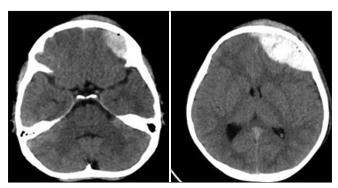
An 8-year-old boy with Glasgow Coma scale 15 and small left frontal extradural hematoma (EDH) (left); repeat computed tomography showing significant enlargement of the EDH (right). He underwent surgery.
